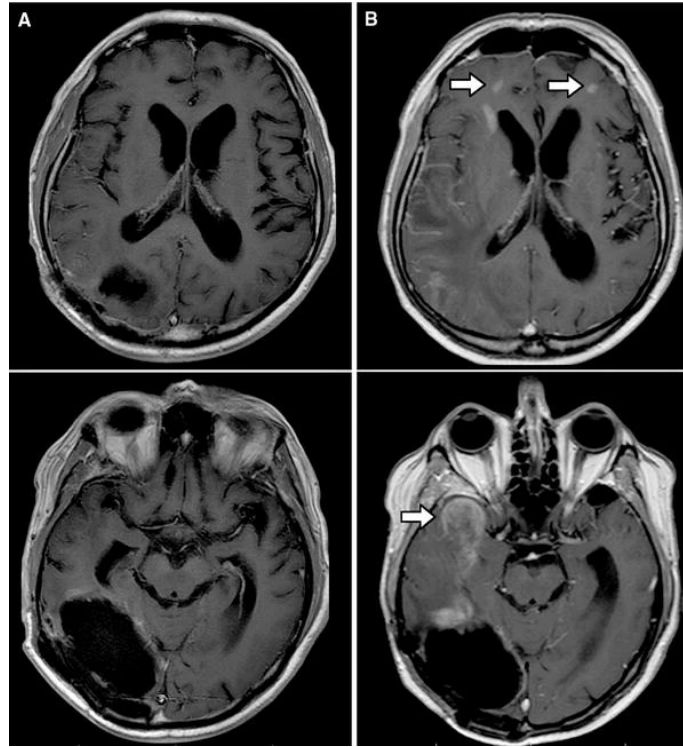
Magnetic Resonance Imaging of GBM. Scans of a patient (A) post-resection and (B) after receiving temozolomide and immunotherapy for 3 months. White arrows indicate regions of recurrence. Figure reproduce with permission from Springer and the Journal of Neuro-Oncology.²⁶
